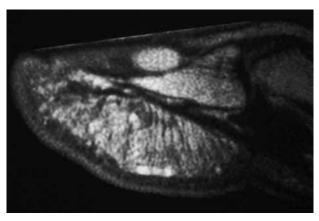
MRI confirmed the diagnosis of glomus tumour (Coll J. André, Brussels, Belgium).
